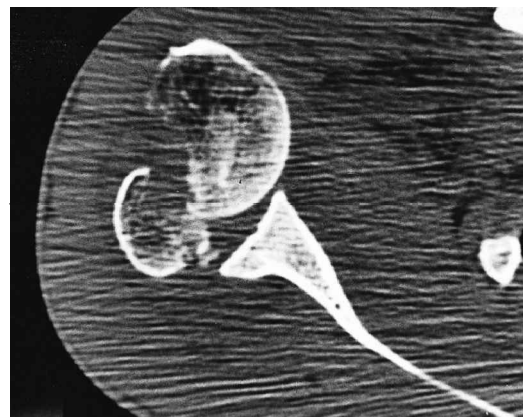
Persistent anterior dislocation of the right humeral head with an unreduced greater tuberosity fragment on CT scan transversal view.
